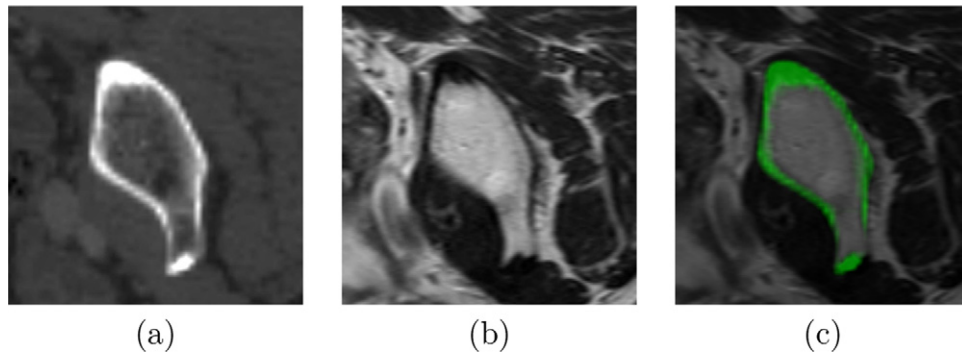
An example CT (a) and MRI scan (b) with accurate registration (c).
